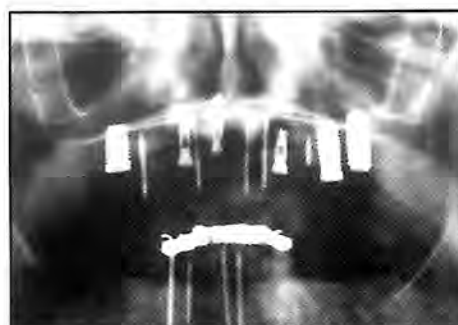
Panoramic radiograph following placement of maxillary implants. At this stage, the implants were submerged to permit healing.
